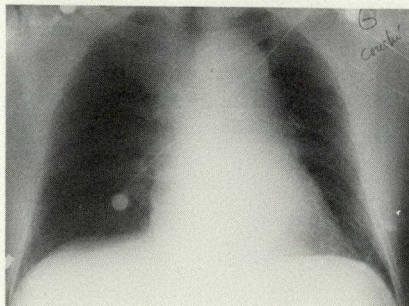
Plain film shows widened mediastinum and double aortic shadow at level of aortic knob.
